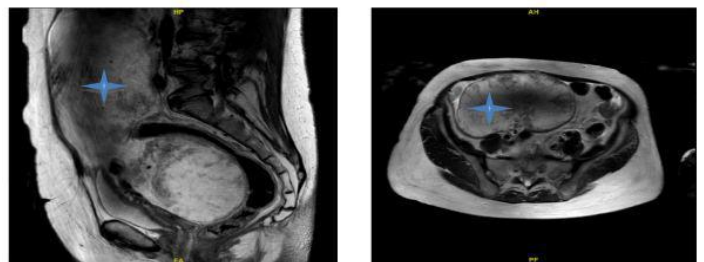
MRI sagittal view T2 (left), axial view T2 (right).
